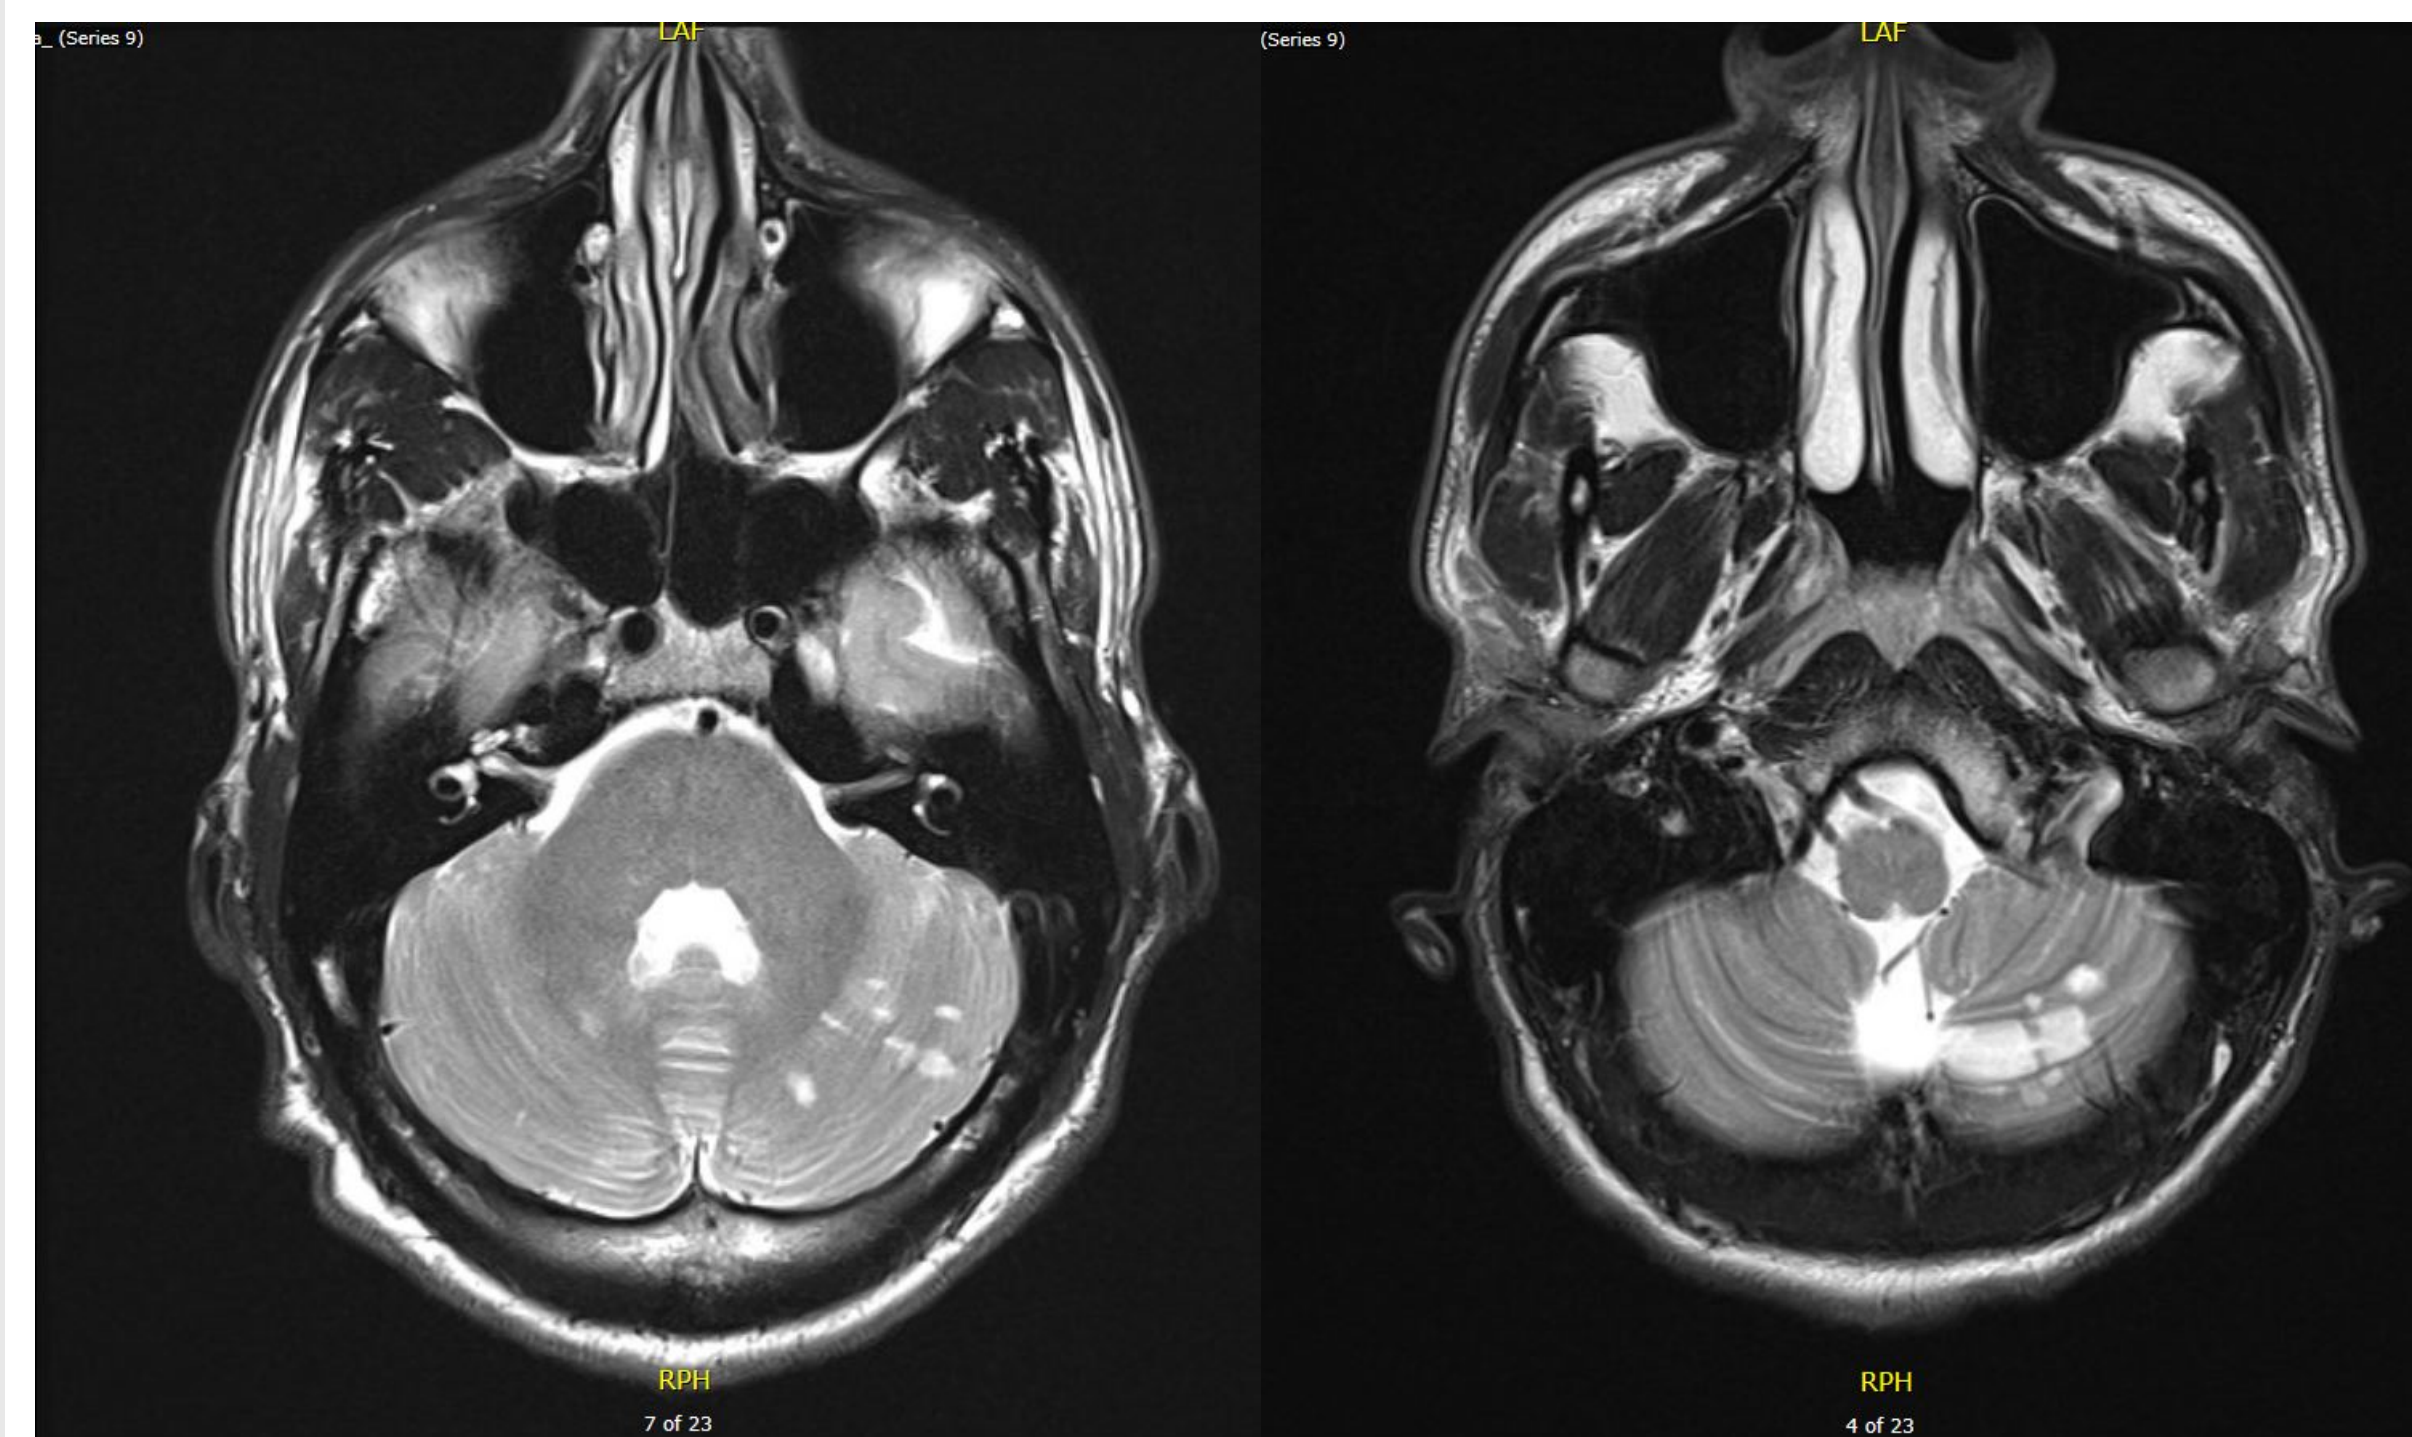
MRI Brain: Multiple punctate foci of restricted diffusion (acute ischemic strokes) in the cerebellar hemispheres and the left occipital lobe
